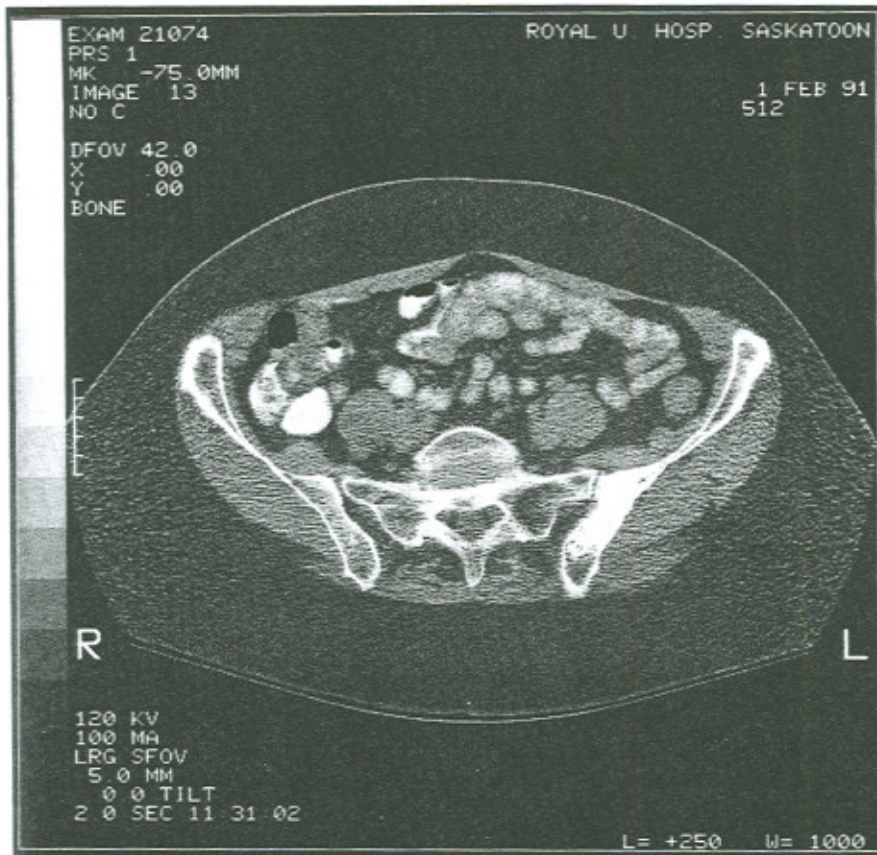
A CT scan shows the sclerotic lesion limited to the left ilium and not involving the sacroiliac joint nor the surrounding soft tissue.
